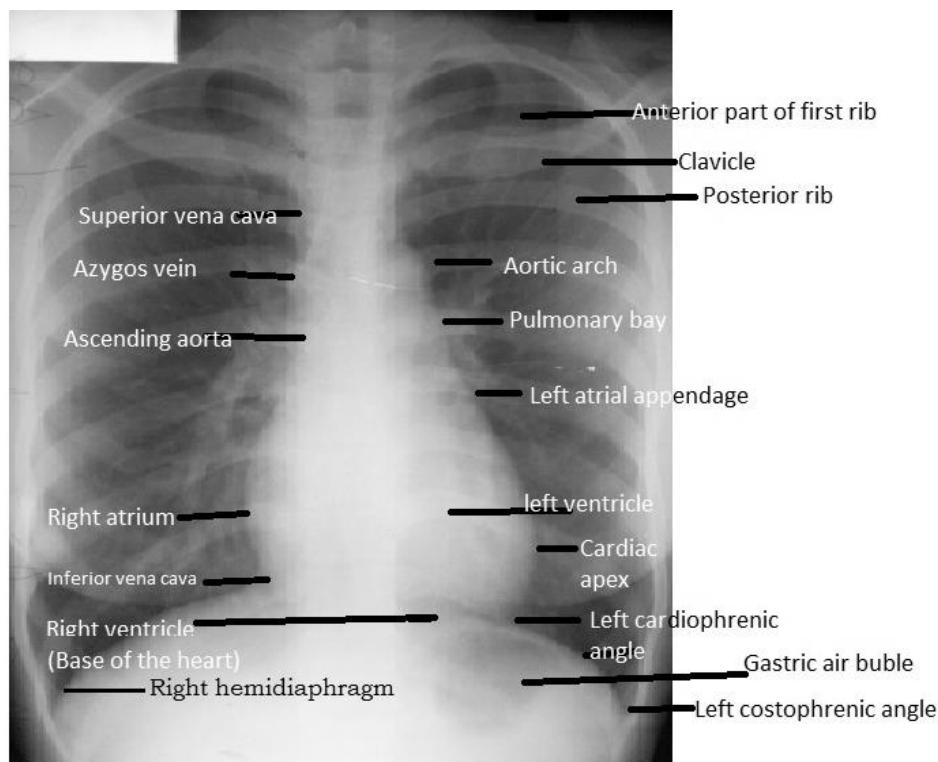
2: Chest radiograph showing the positions of cardiac chambers.
